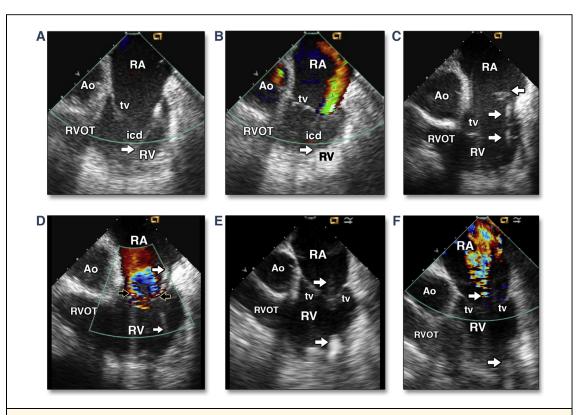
Intracardiac Echocardiographic Images of Intracardiac Device Lead and Tricuspid Regurgitant Severity With Different Etiologies
